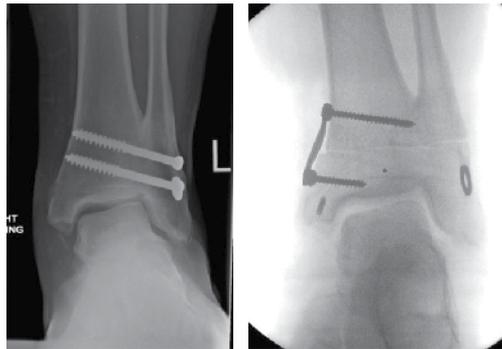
Radiographic images of medial closing wedge osteotomy after a distal tibial-fibular fusion resulted in lateral joint overload. Right image is an intraoperative fluoroscopic view after fixation with a compression staple.
